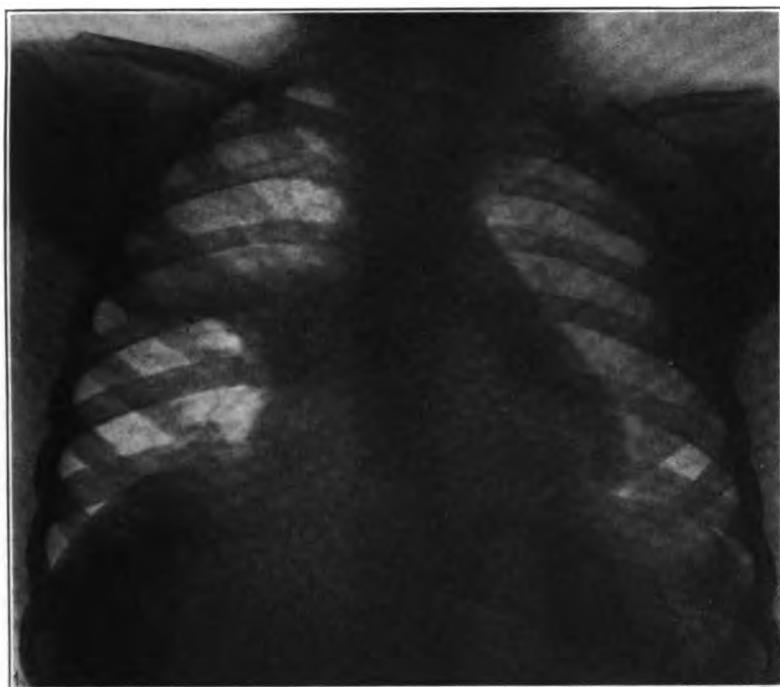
(Case 2). Radiograph taken June 3, 1915. Enlarged bronchial lymph nodes surrounding right lower bronchus. Triangular shadow of infiltration in right upper lobe bounded below by the interlobar fissure.
